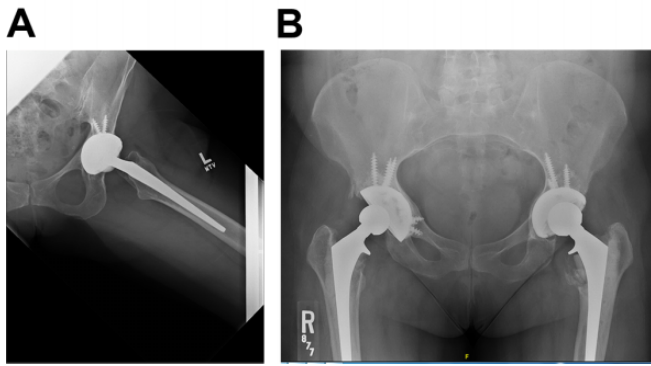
(A) In assessing the preoperative anteroposterior pelvic radiograph in patients after total hip arthroplasty, it is important to evaluate cup position, medial wall integrity, and new bone formation, particularly in relation to the anterior rim of the acetabulum. (B) Preoperative lateral pelvic radiograph showing anterior undercoverage of the prosthetic cup.
